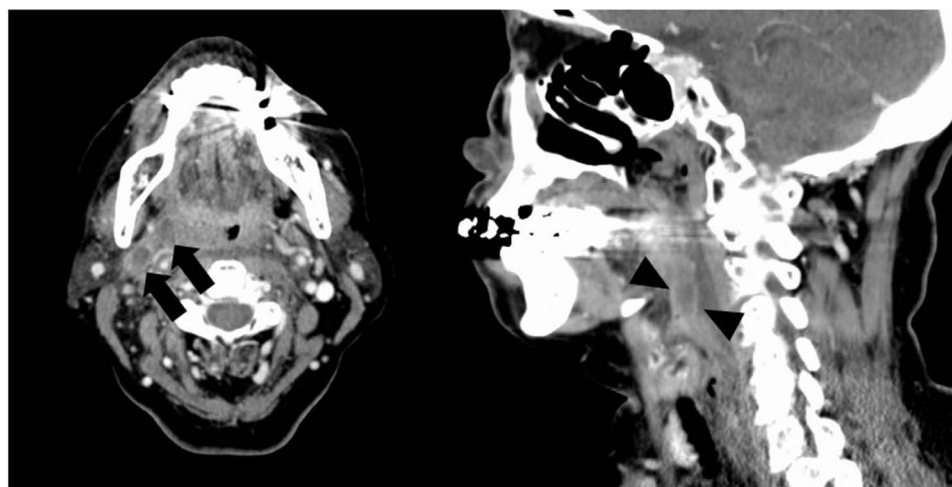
Enhanced computed tomography of the neck. Black arrow indicates a right peritonsillar abscess. Black arrowhead shows a retropharyngeal abscess.
